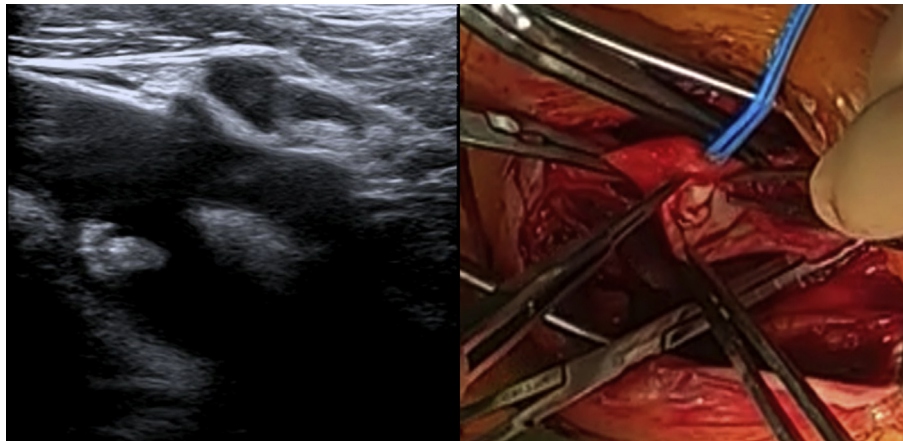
Cervical duplex ultrasound showing a mobile, ruptured internal carotid plaque (left). Per-operative findings showing the floating plaque through the carotid arteriotomy (right).
